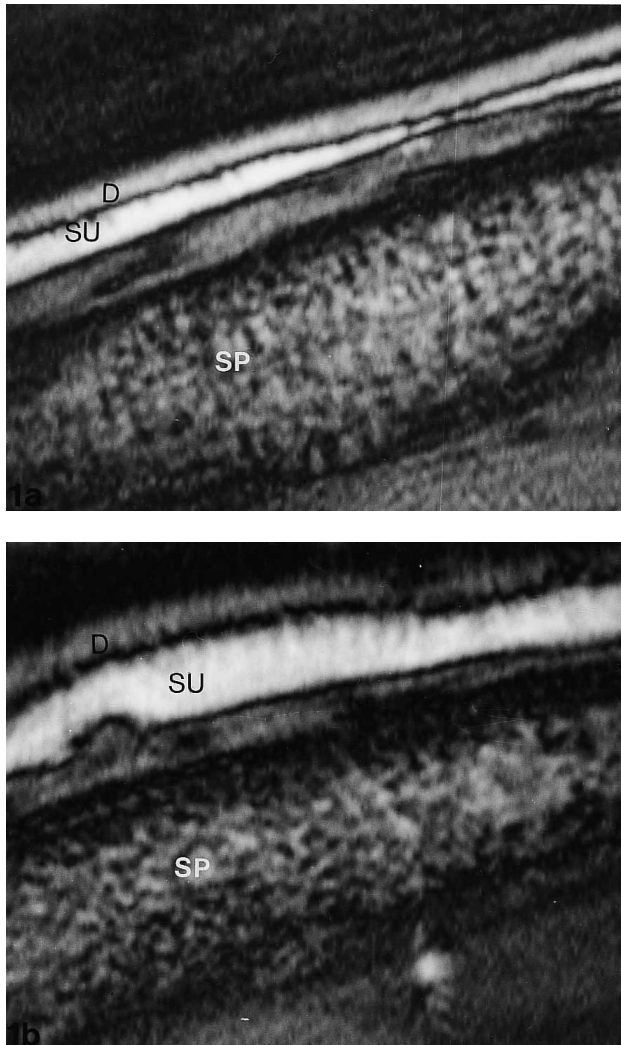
A 60-year-old woman with clinical stage 2–3 progressive facial haemiatrophy. Magnetic resonance imaging stage 2. MRI of the skin (temple). T1-weighted transverse image (500/25, ACQ 3, matrix 256×256 , slice thickness 2 mm). (a) Affected side. Both subcutis and dermis are thin, in particular, there is a variable subcuticular thickness. There is no dermal interdigitating. There is a chemical shift artifact between the dermis and the subcutis. The epidermis cannot be discerned. (b) Healthy contralateral skin. Hypointense dermis, underlying subcutis. D: dermis; SU: subcutis; SP: spongiosa.
